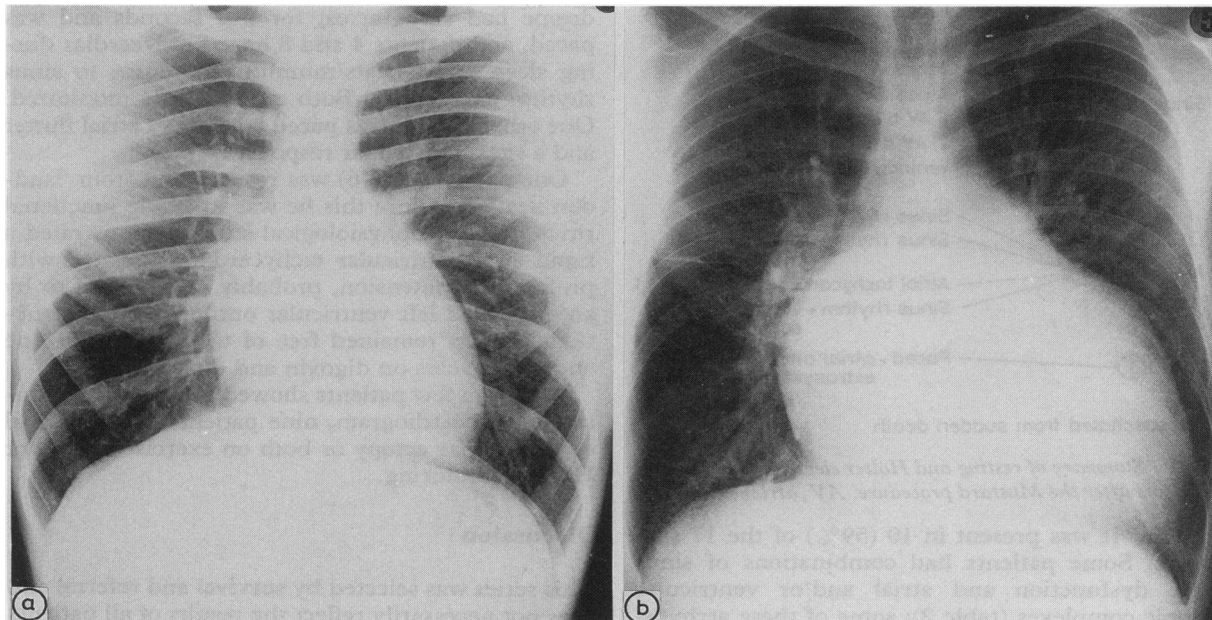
(a) Chest radiograph of patient 5 at 19 years of age. At this time he had mild tricuspid regurgitation and an ability index of 2. His cardiothoracic ratio was 50%. (b) Chest radiograph six years later when he had severe tricuspid regurgitation and an ability index of 3. His cardiothoracic ratio was 73%.
